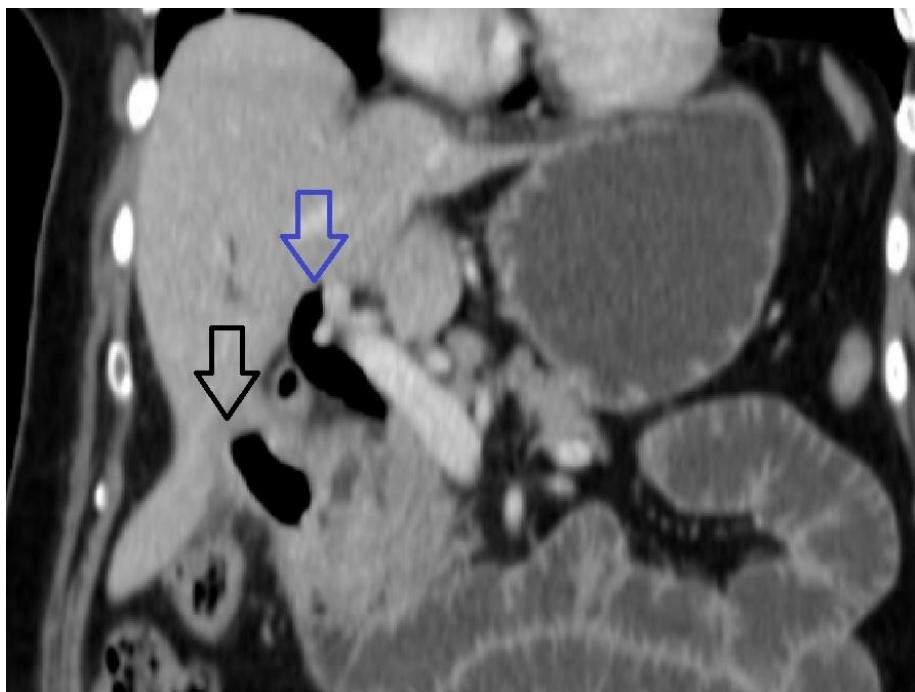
Coronal image from contrast-enhanced computed tomographic scan. A cholecystoduodenal fistula (black arrow) was observed with resulting gas in the gallbladder and biliary tree (blue arrow).
